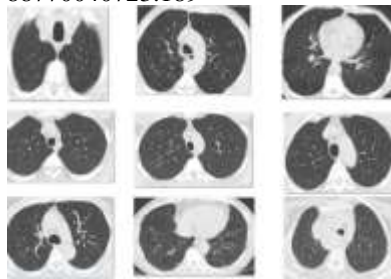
CT scans images of SARS-CoV-2 infection -ve samples in axial projection
